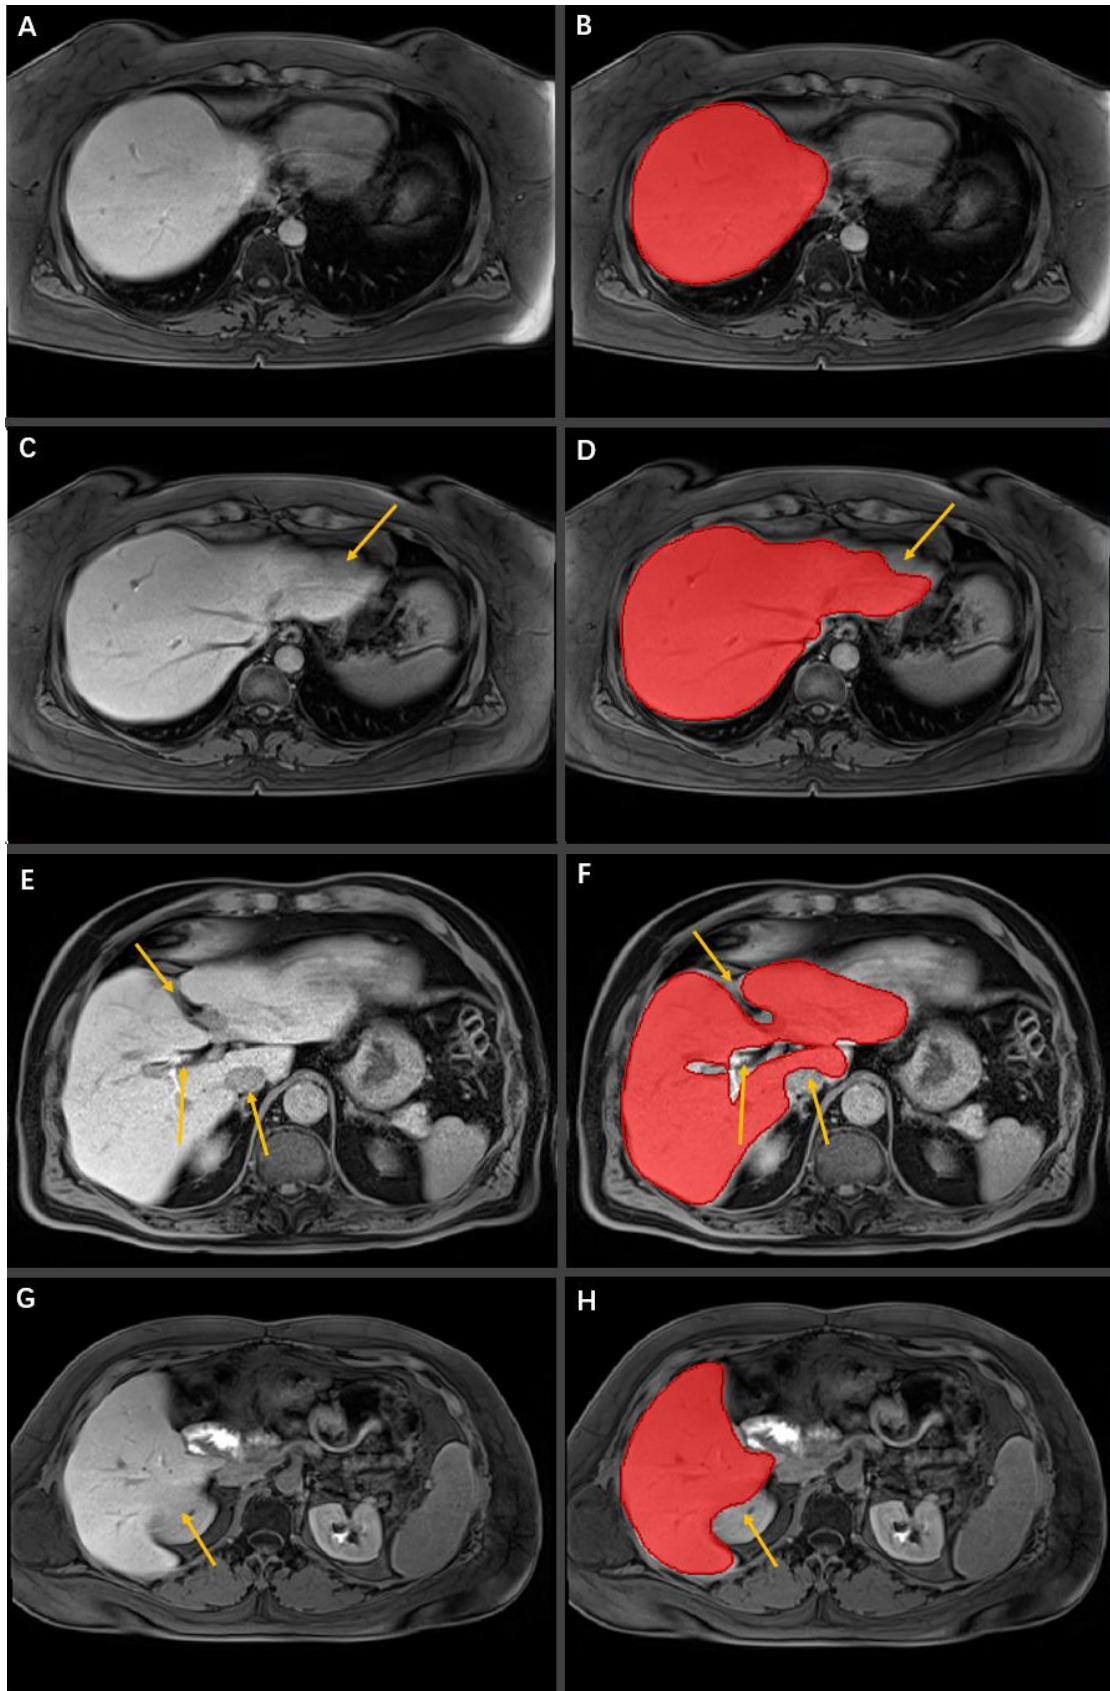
Manual segmentation of the liver (red areas in B, D, F, H) on different slices of the HBP sequence 20 min post Gd-EOB-MRI (A, C, E, G). Yellow arrows indicate the mediastinum (C, D), hepatic ligament, portal vein, inferior vena cava (E, F), and kidney (G, H), respectively.
